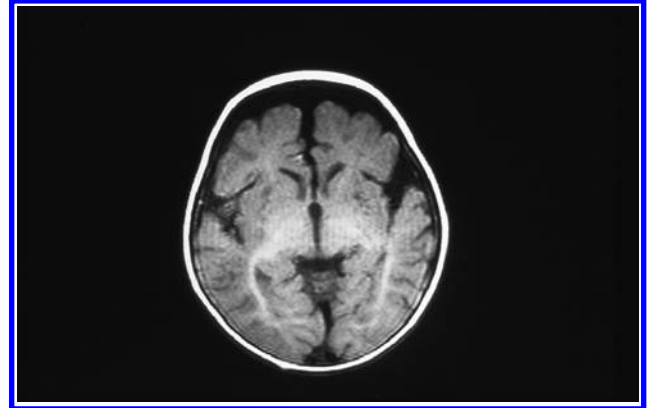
Computed tomographic scan of the brain of NS showed frontotemporal atrophy.
